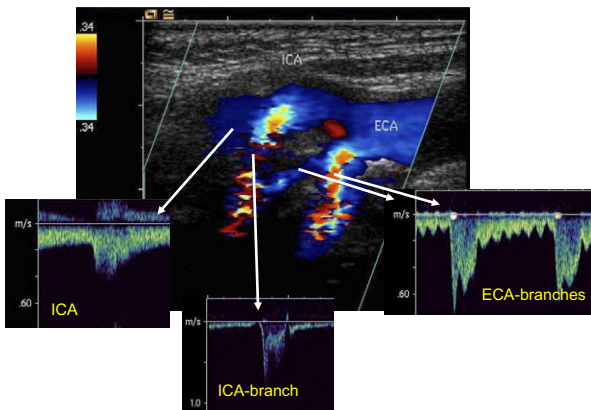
Duplex sonography scans show internal carotid artery (ICA) with a branch (ICA-branch) and external carotid artery (ECA) with branches (ECA-branches).
